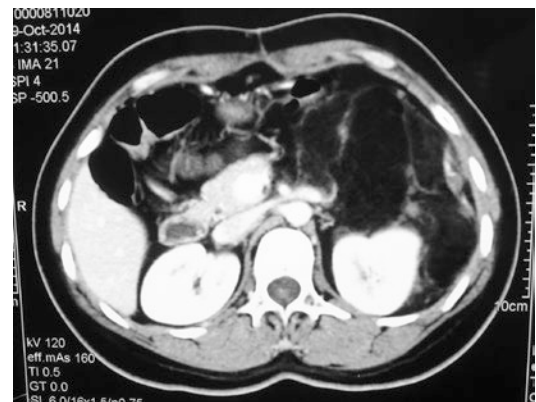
Image (CT) of the retroperitoneal tumor in the left upper quadrant
